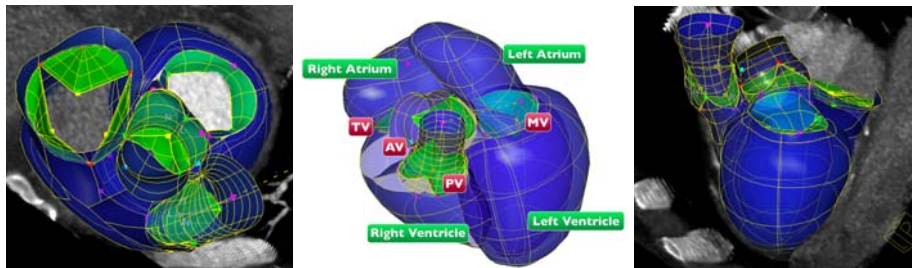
Examples of personalized model estimated from a multiphase CT sequence.
